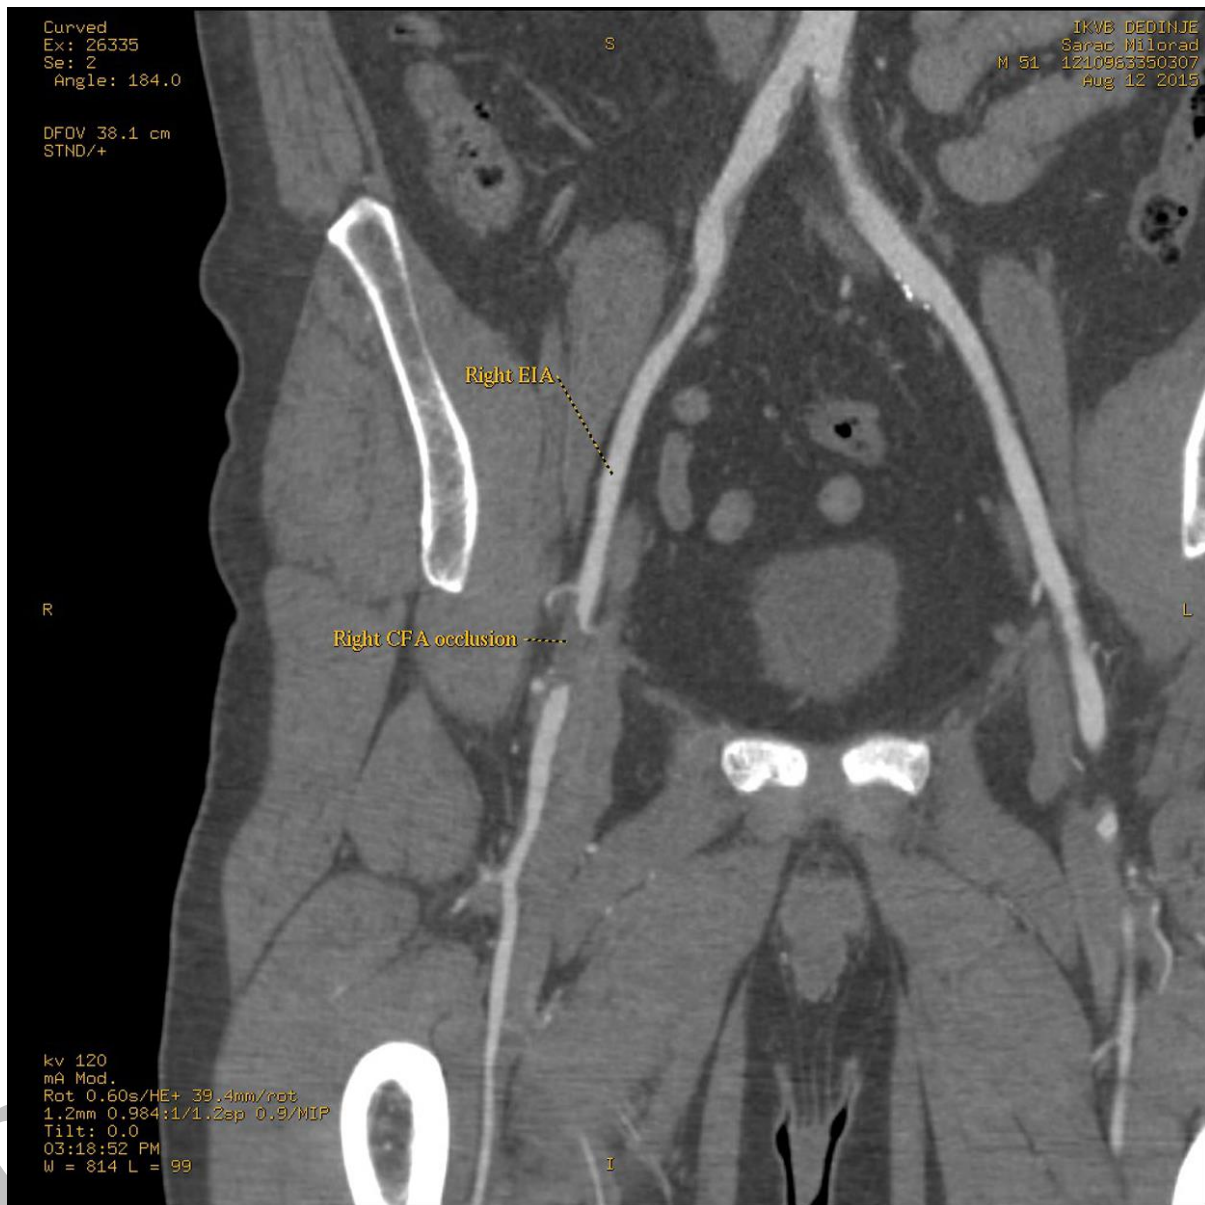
Multidetector computed tomography angiography; chronic total occlusion of the right common femoral artery (CFA) without any signs of thrombosed dissection prior to angioplasty attempt
